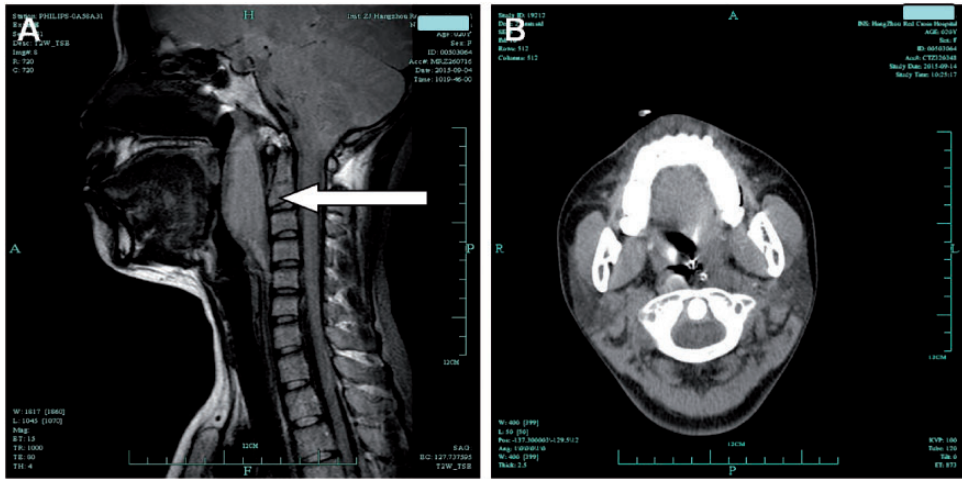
a, Neck MRI shows a fusiform long T1 and T2 signal shadow in the retropharynx with the upper edge reaching the nasopharynx and the lower edge reaching the epiglottis. The purulent lumen of the retropharynx (with arrow). b, Neck CT shows that the RPA was absorbed
